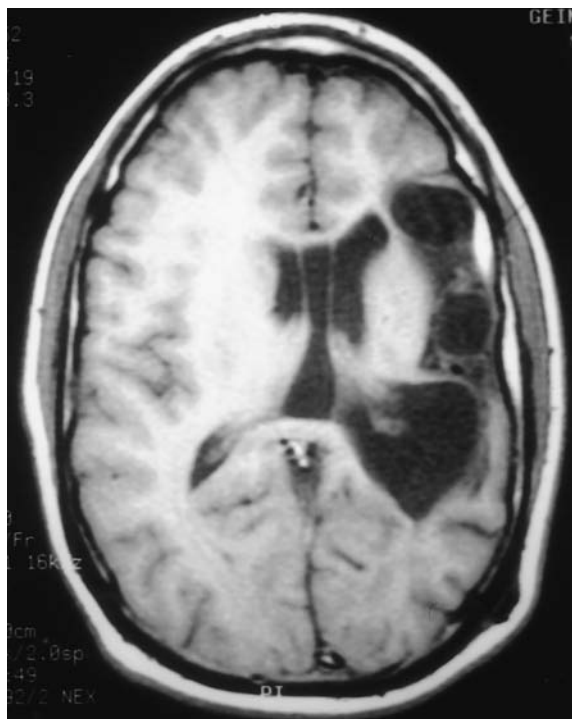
Preoperative axial T1 MRI sequence of an 18-year-old man with congenital right hemiparesis and intractable seizures. There is broad left middle cerebral territory infarction and mild ex vacuo left ventricular dilation.
